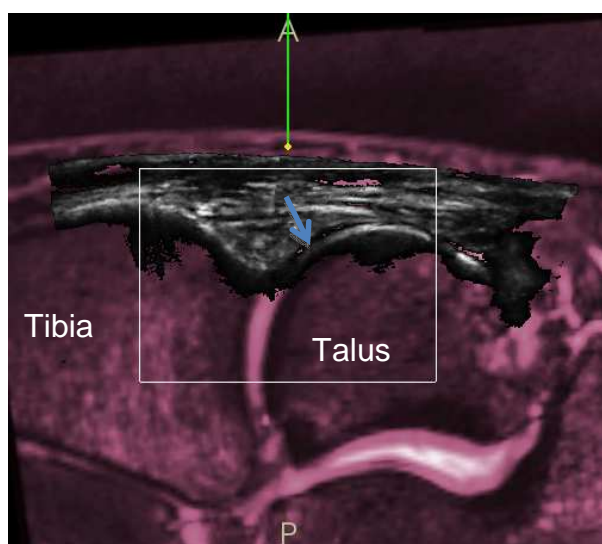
To the left, the distal end of the tibia, and in the middle, the talus. The multimodal display of US acquisition (black and white) and MRI (purple) shows excellent correspondence of anatomical structures: cortical bone (black in MRI, white in US), and the cartilage layer (purple in MRI) shows through the corresponding
